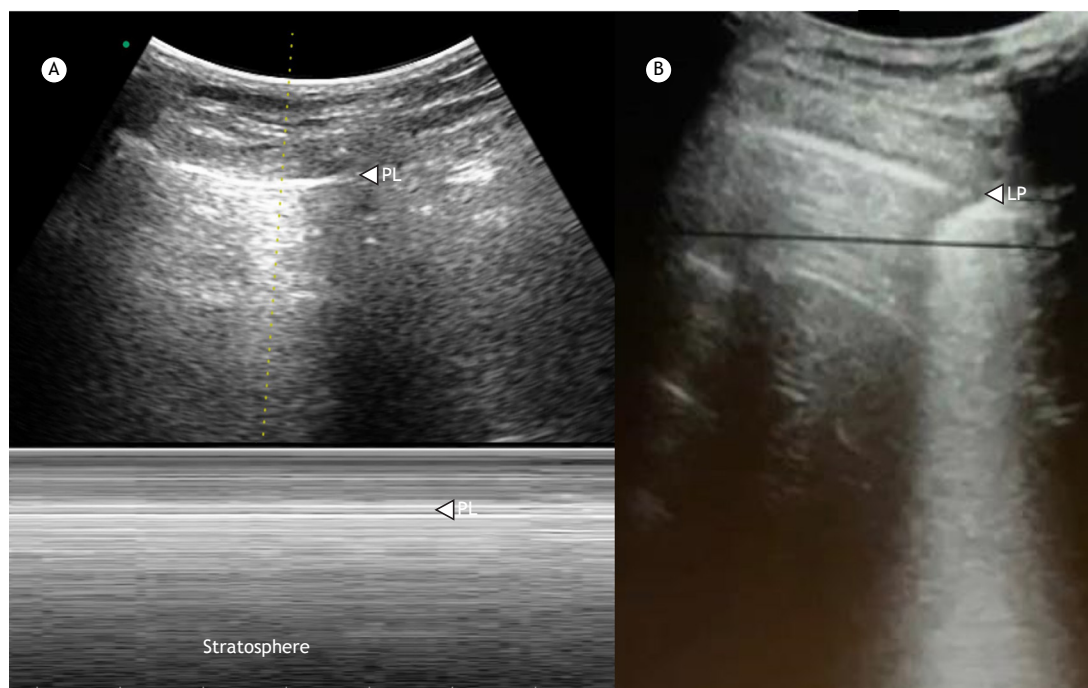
Pneumothorax. a) Motion (M)-mode findings in pneumothorax: if lung sliding and the lung pulse are absent, there will be no change in the area below the pleural line in the two-dimensional (2D)/brightness (B)-mode image. In M-mode, horizontal lines will be seen above and below the pleural line (PL), and the seashore sign can no longer be identified. The M-mode pattern has been described as resembling a barcode or a stratosphere and is therefore known as the barcode sign or stratosphere sign, which can be seen when a pneumothorax is present, as well as in conditions in which lung sliding and the lung pulse are absent (e.g., pleural adhesions). b) 2D-mode showing the lung point (LP). The LP is an ultrasonographic sign that is used in order to locate the junction between the pneumothorax and the area with no air between the visceral and parietal pleura and refers to a pattern of repeated transitions between no lung sliding or B-lines (pneumothorax) into a demonstrable area of lung sliding.
